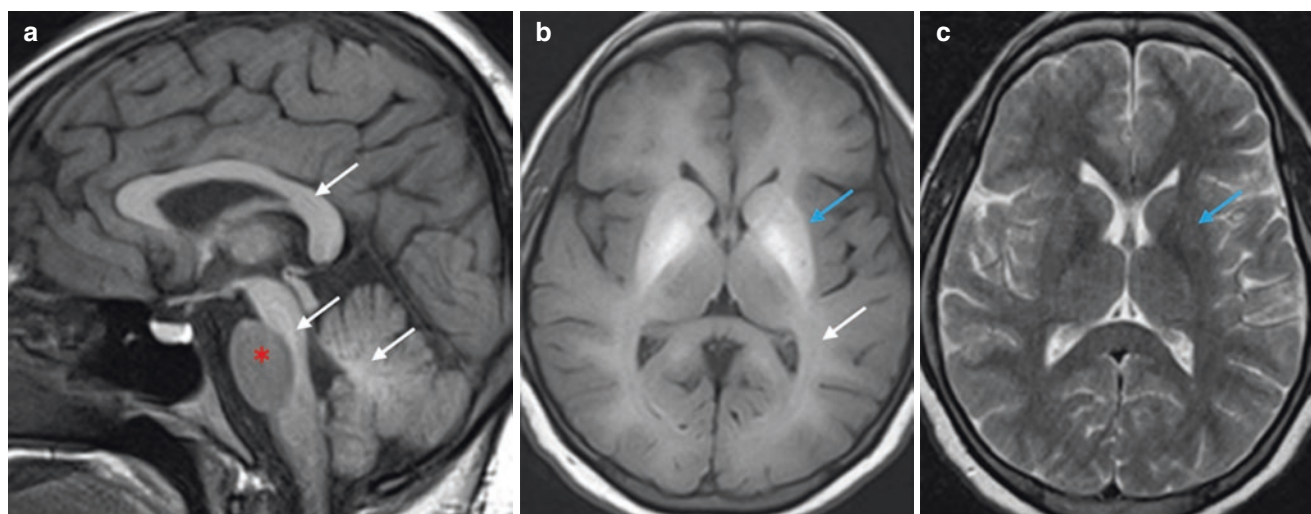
Characteristic MRI brain appearances due to manganese overload in *SLC30A10* (HMNDYT1) and *SLC39A14* (HMNDYT2) transporter defects (Tuschl et al. 2016). (a, b) T1-weighted MR imaging shows hyperintensity of the globus pallidus and striatum (blue
